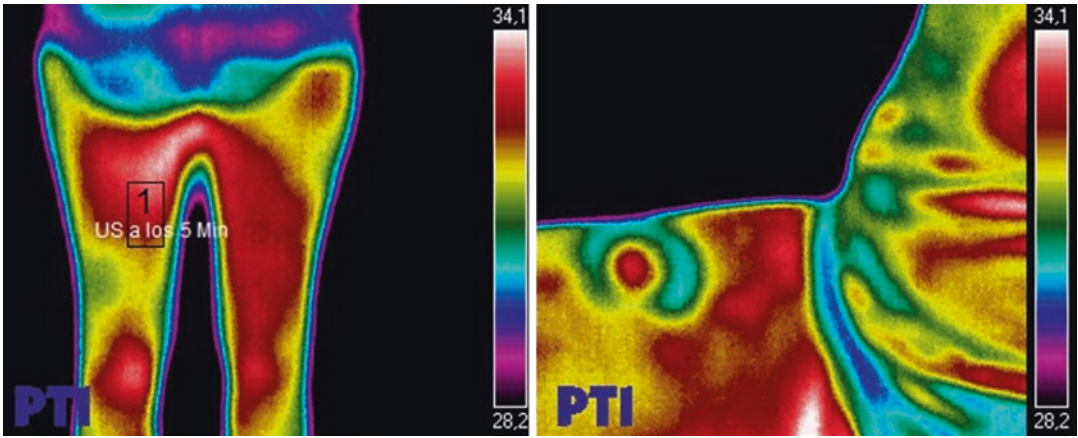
Using thermography to measure the temperature and evaluate the effect of ultrasound
